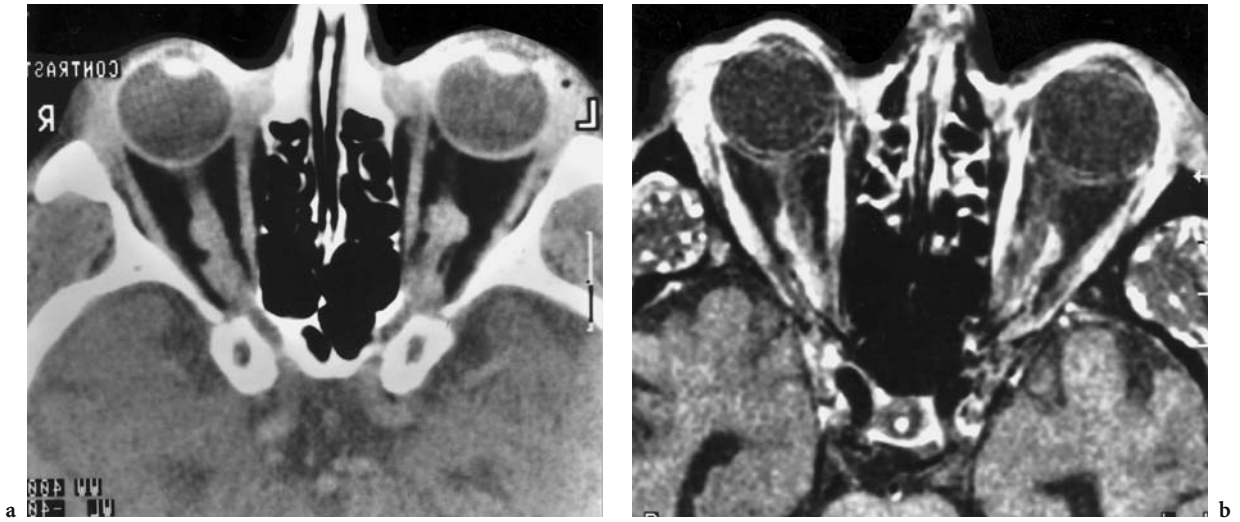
A 76-year-old man with systemic NH-lymphoma and acute visual disturbance. Diagnosis: meningeal metastasis of NH-lymphoma. CT: a Axial contrast-enhanced image with knotty, bulbar structures in the course of the optic nerve. MRI: b Corresponding axial, T1-weighted, contrast-enhanced (FS) image confirming the diagnosis of meningeal tumor spread with bilateral tumor seeding along the meningeal sheaths in the presence of regular signal and normal formation of both optic nerves. (With permission of MÜLLER-FORELL and LIEB 1995)
